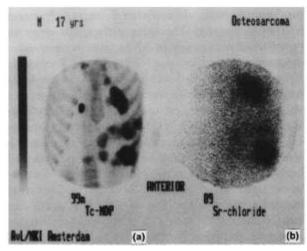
Bone scintigraphy using [99mTc]MDP (a) in a 17-year-old male with intense accumulation in pulmonary metastases from osteosarcoma; image (b) shows the scintigram using the Bremsstrahlung 24 h after therapy with 370 MBg [89Sr]chloride.
